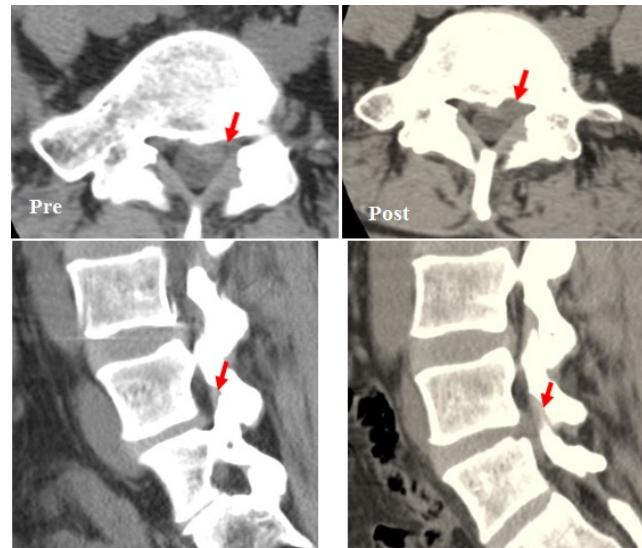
Preoperative and postoperative CT imaging showed the lateral recess enlarged and the tip of the facet joint was removed.
